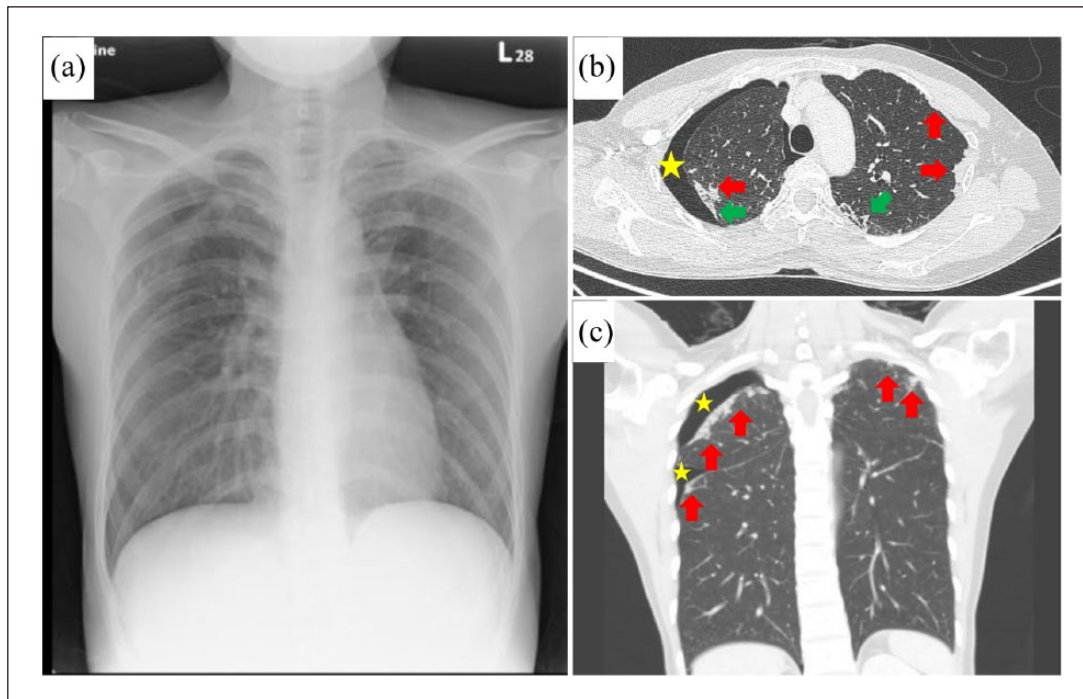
Image of the patient showed right side pneumothorax in a supine chest X-ray (a). Computed tomography of the chest (b) and (c) showed consolidations (red arrow) and reticular opacities (green arrow) involving bilateral pleural and subpleural regions indicating fibrosis at upper and middle lung zones, in addition to the right pneumothorax (yellow star).
